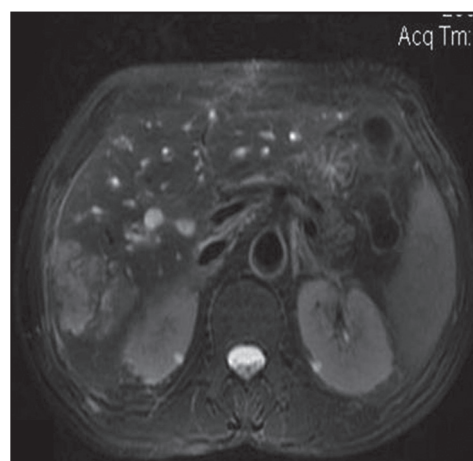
T2-weighted image of gall bladder mass showing metastasis in right lobe of liver
